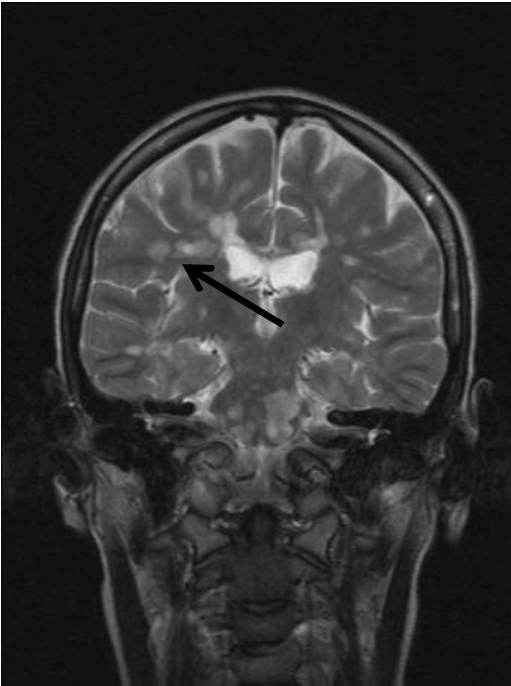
T2 MRI of a 15-year-old girl with multiple sclerosis lesions.
